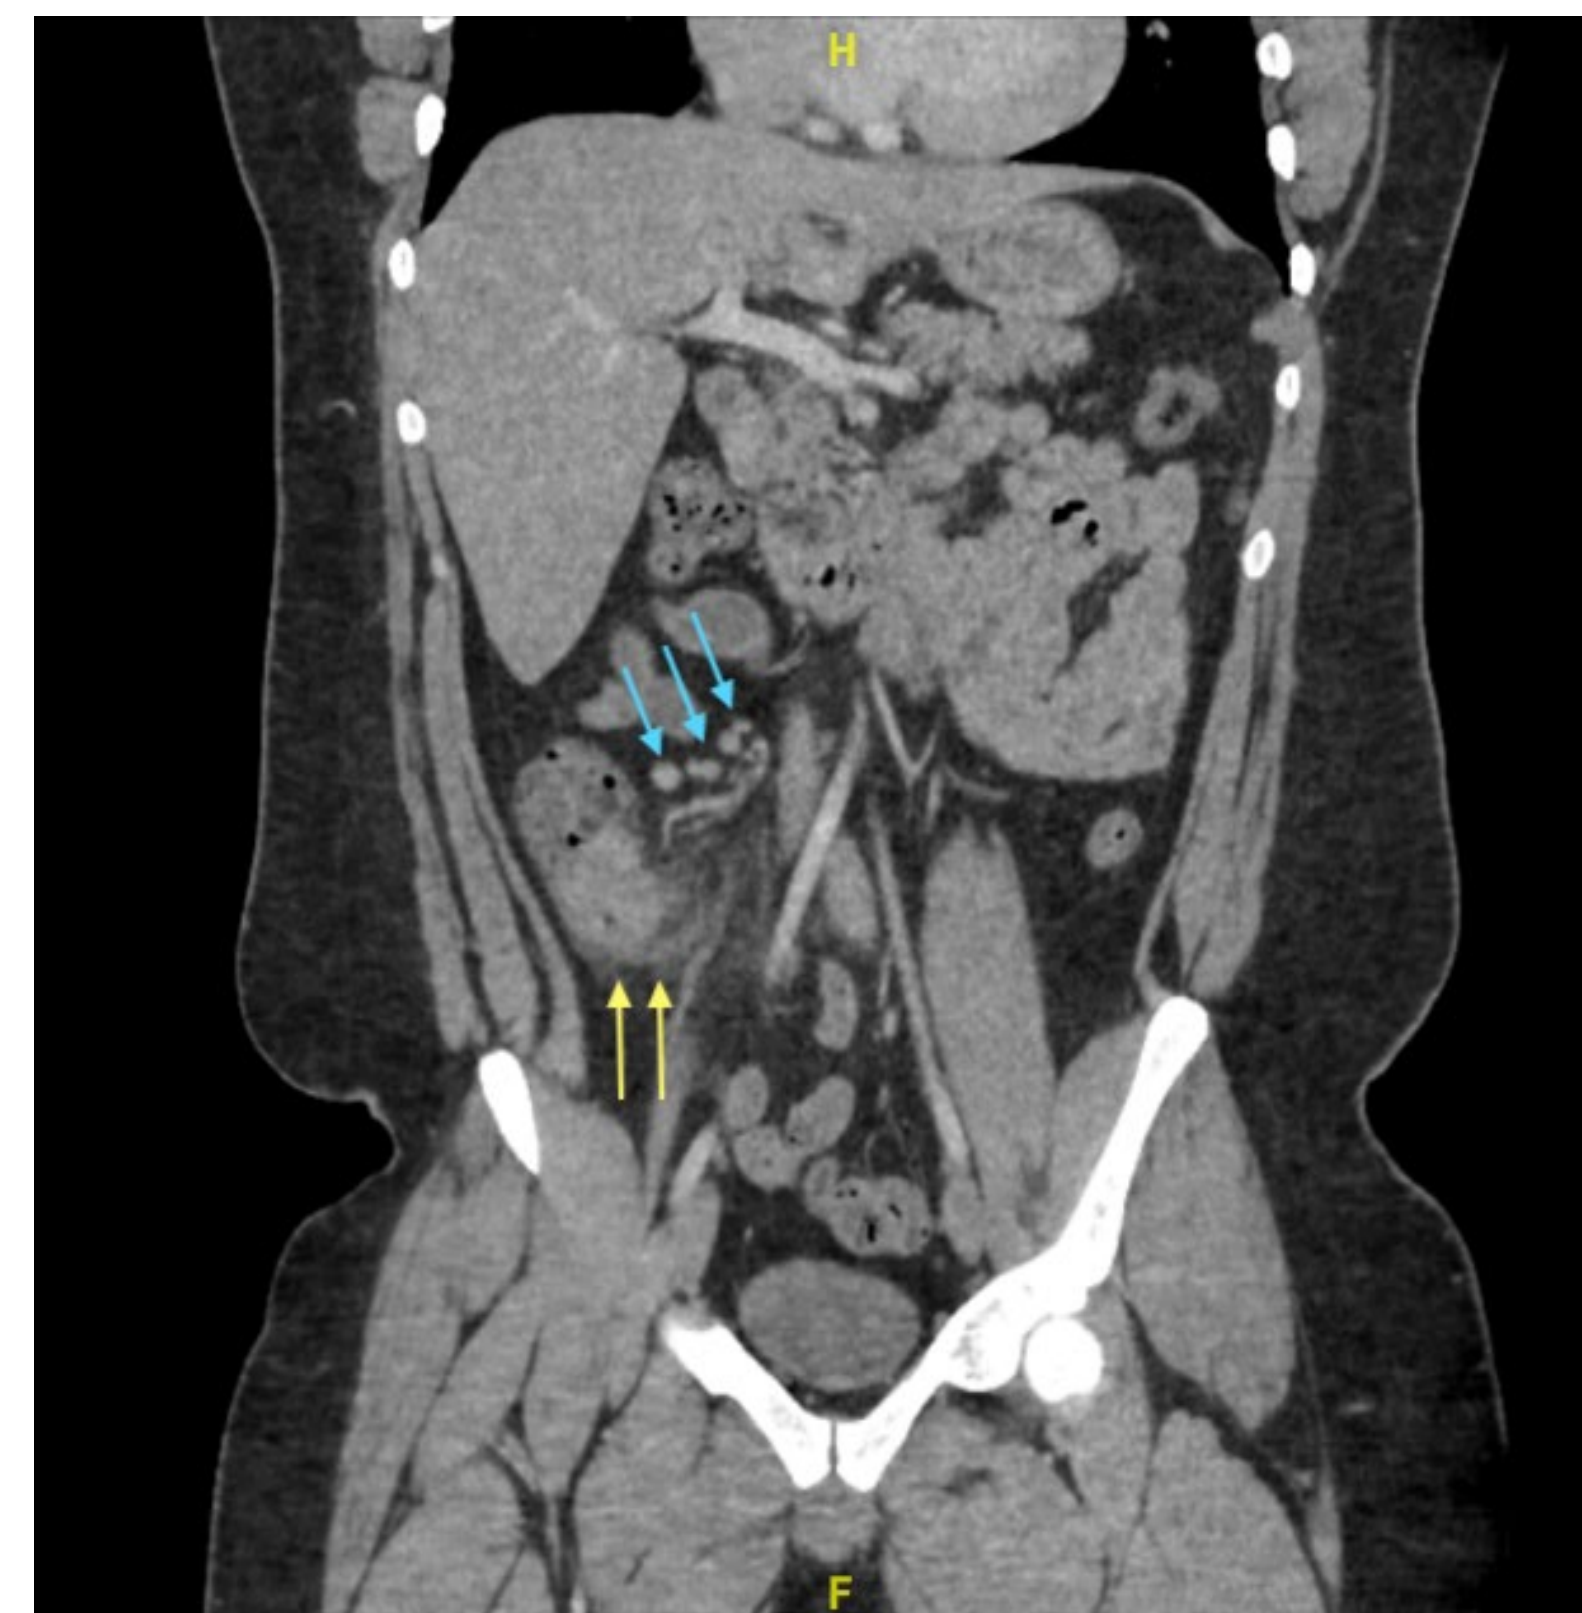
CT abdomen and pelvis with IV contrast on admission, coronal; perienteric inflammation and surrounding pericecal fat stranding (yellow arrows) with prominent right lower quadrant lymph nodes (blue arrows). These findings are consistent with acute appendicitis but the appendix was not visualized on imaging of this patient in any view.
